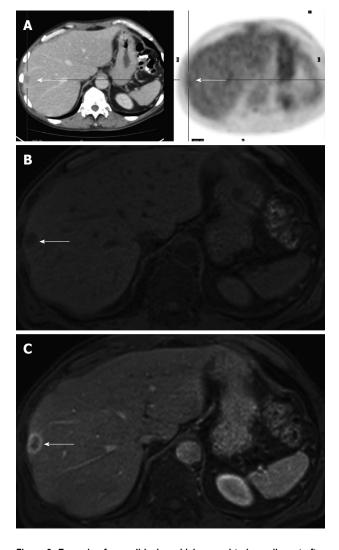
Example of a small lesion which proved to be malignant after follow-up. A: Positron emission tomography (PET)/computed tomography negative (PET-cold) focal liver lesion (white arrow) in a patient who received chemotherapy in the past; B: Corresponding T1w Gradient Echo magnetic resonance imaging (MRI) image before injection of contrast agent shows a rather hypo-intense focal liver lesion (white arrow); C: Corresponding T1w Gradient Echo MRI image in the venous phase after injection of contrast agent shows a hypo-intense focal liver lesion with ring-enhancement compatible with an (active) malignant focal liver lesion (colorectal cancer liver metastasis) (white arrow).
